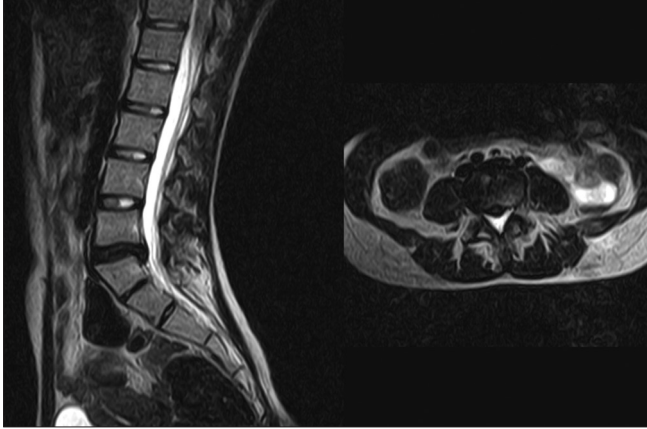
Pre-operative magnetic resonance imaging of the lumbar spine revealed a lumbar disc herniation at the L5-S1 level
